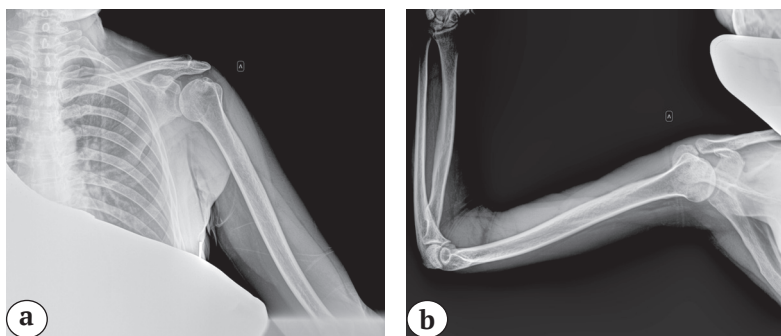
X-rays of left shoulder of the patient:
